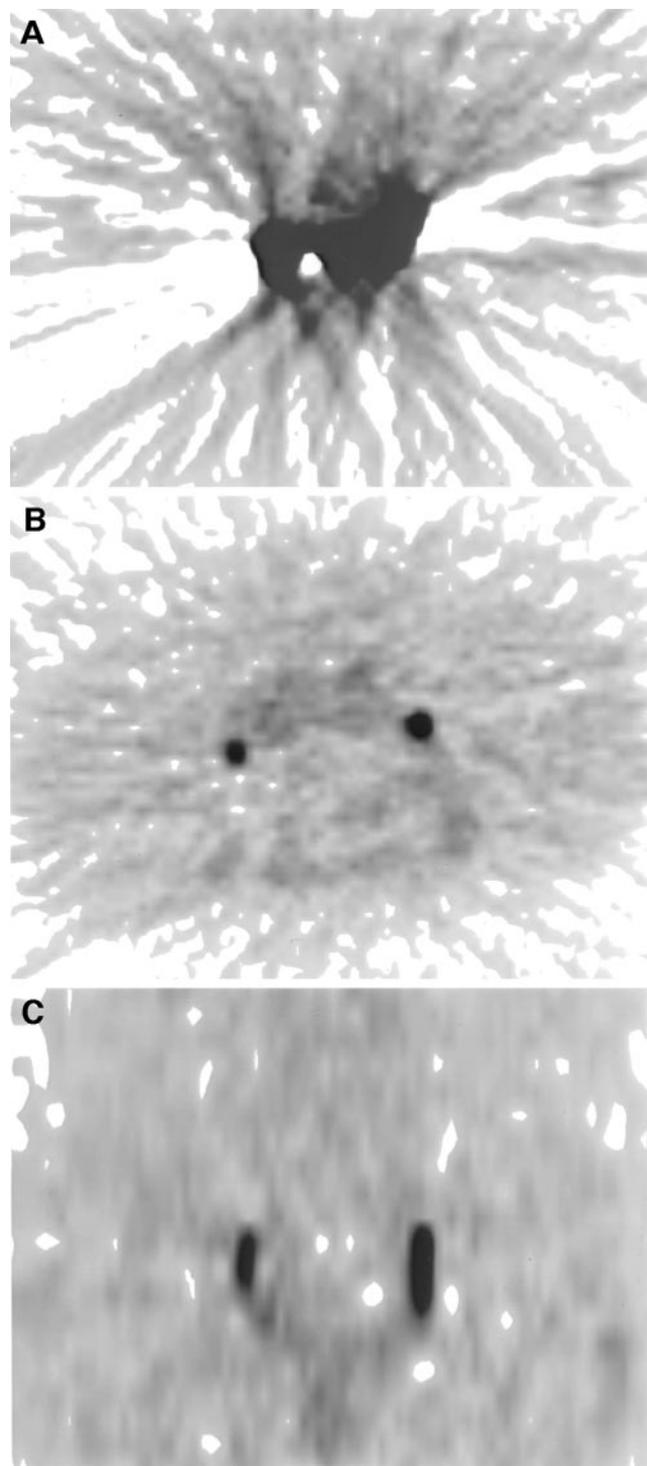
(A) Strong artifact caused by residual ^{18}F -FDG activity in urinary bladder because of insufficient bladder irrigation (patient 33). Detection of tumor ^{18}F -FDG accumulation was easy because slice level of tumor ^{18}F -FDG accumulation was not same as slice level of artifact. (B) Residual ^{18}F -FDG detected in left and right ureters after bladder irrigation (patient 24). One cannot easily differentiate ^{18}F -FDG accumulation in ureter from that in metastatic lymph node by these axial images alone. (C) Reconstruction of coronal images facilitates diagnosis of ^{18}F -FDG accumulation in ureters.
